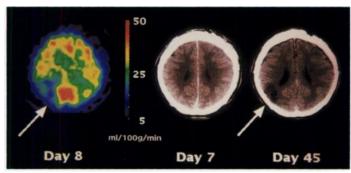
In Patient 8, the rCBF image (left) demonstrated severe hypoperfusion (13.9 ml/100 g/min) in the territory of the right middle cerebral artery at Day 8. The patient was tetraplegic. The CT image at day 7 (center) disclosed no evidence of infarction. The corresponding area later developed brain infarction (right).
